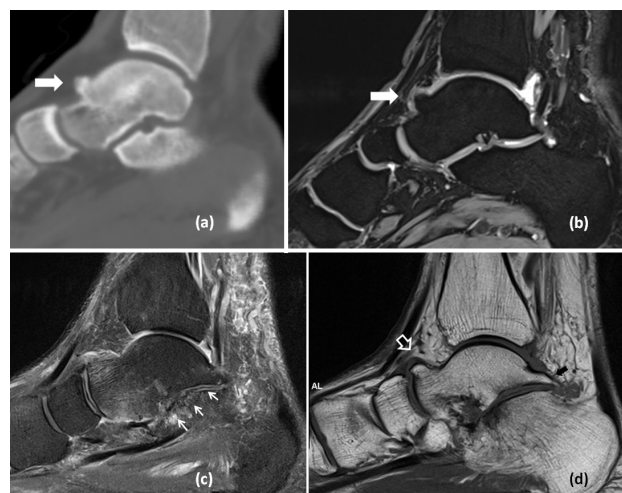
Hypertrophic talar ridge (thick arrows) is shown in the sagittal reformatted CT (a) and corresponding sagittal T2-weighted 3-D gradient echo images (b) of the right ankle of a 26-year-old professional football player. In another patient with fibrous coalition of the middle subtalar joint, associated degenerative changes (arrows) are shown on sagittal T2-weighted fat suppressed MR image (c). On T1-weighted image (d) the talar beak (open arrow) is observed at the superior margin of the talar head in this 64-year-old male patient. Note that he also has a prominent Stieda process on the posterior aspect of the talus (black arrow).
